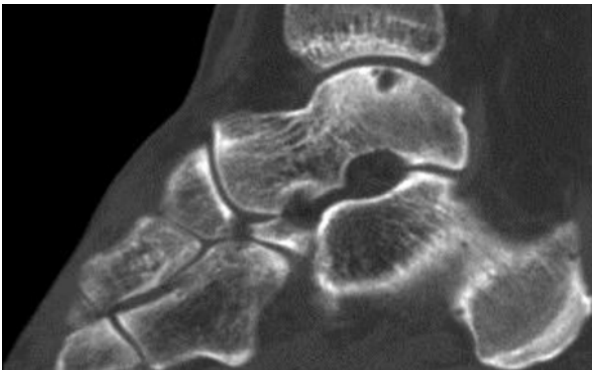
CT scan of a lateral osteochondral defect, coronal reconstruction
